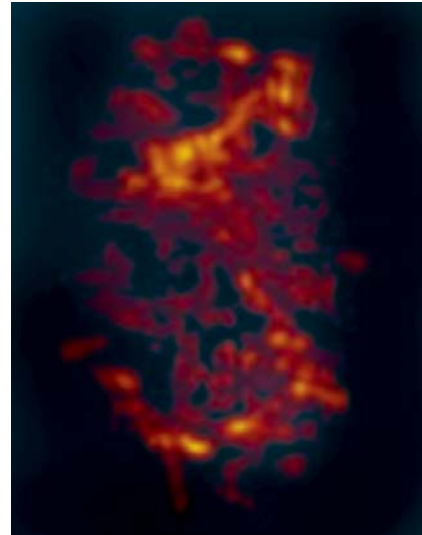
Power Doppler mapping reveals a spoke wheel pattern vascularity in the adenomyoma
